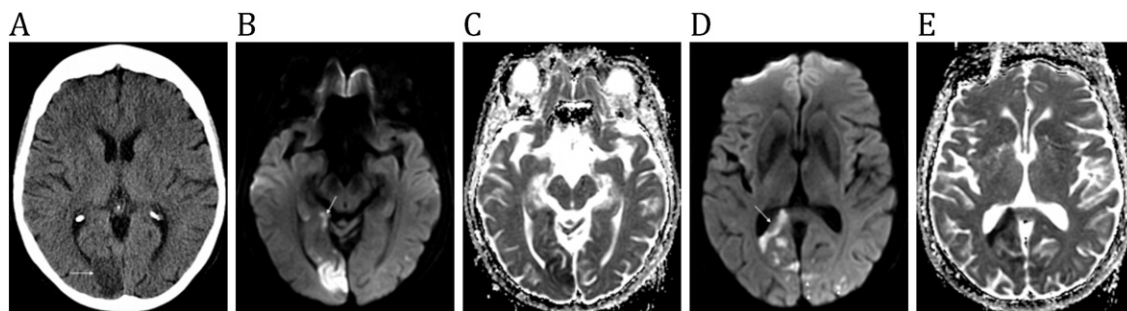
Axial noncontrast CT at presentation (A) shows a low attenuation infarct in the right occipital lobe (arrow). MRI demonstrates more extensive high signal areas on axial diffusion weighted images (B, D) and low signal areas on the corresponding apparent diffusion coefficient maps (C, E) consistent with diffusion restriction and acute infarcts. Infarction in the splenium of the corpus callosum (arrow, D) indicates compromise of the posterior pericallosal artery branch from the posterior cerebral artery, and punctate infarcts in the left occipital lobe (arrowheads, D) indicate compromise of distal branches of the contralateral posterior cerebral artery.
